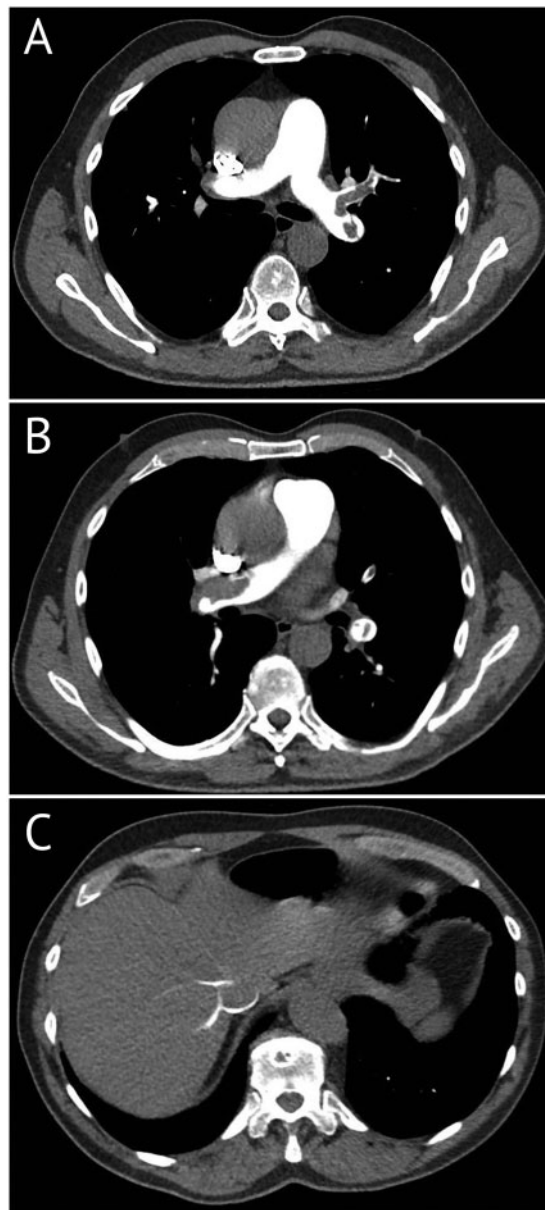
(A) Computed tomography pulmonary angiogram demonstrating multiple pulmonary emboli in the left lobar arteries; (B) computed tomography pulmonary angiogram demonstrating a large thrombus in the right pulmonary artery; (C) computed tomography pulmonary angiogram demonstrating retrograde opacification of the hepatic veins indicating right heart strain.
